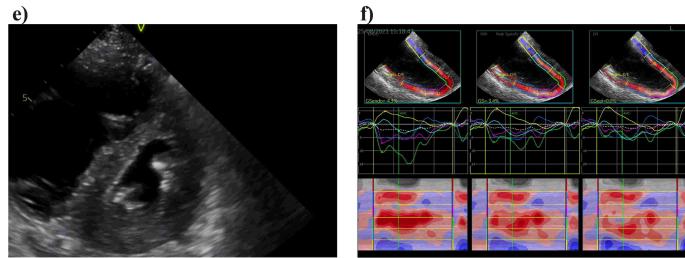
Examples of echocardiographic parameters for assessing the right ventricular dysfunction. (a) tricuspid annular plane systolic excursion of 16 mm. (b) pulsed tissue Doppler S wave (S') of 6 mm. (c) fractional area change of the right ventricle. (d) right ventricular size in three-dimensional mode. (e) interventricular septal flattening. (f) regional longitudinal shortening of the right ventricle with strain echocardiography.
